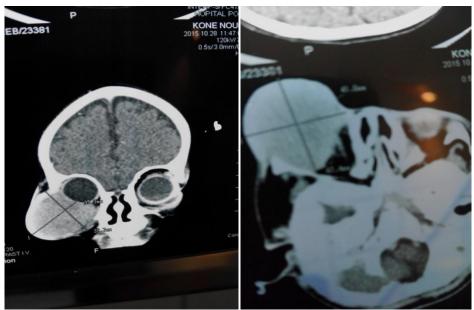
CT Scan showing the right eye rhabdomyosarcoma
